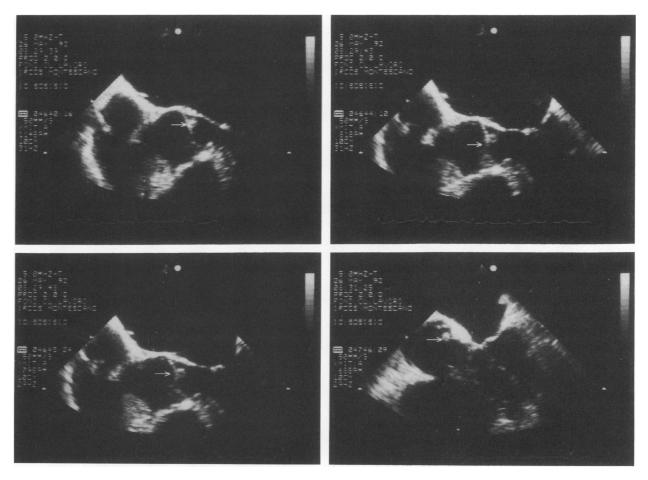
With the aid of transesophageal echocardiography, it is possible to visualize a small mass, only 5 mm in diameter, adherent to the coronary cusp of the aortic valve (arrows). (Patient 31)
